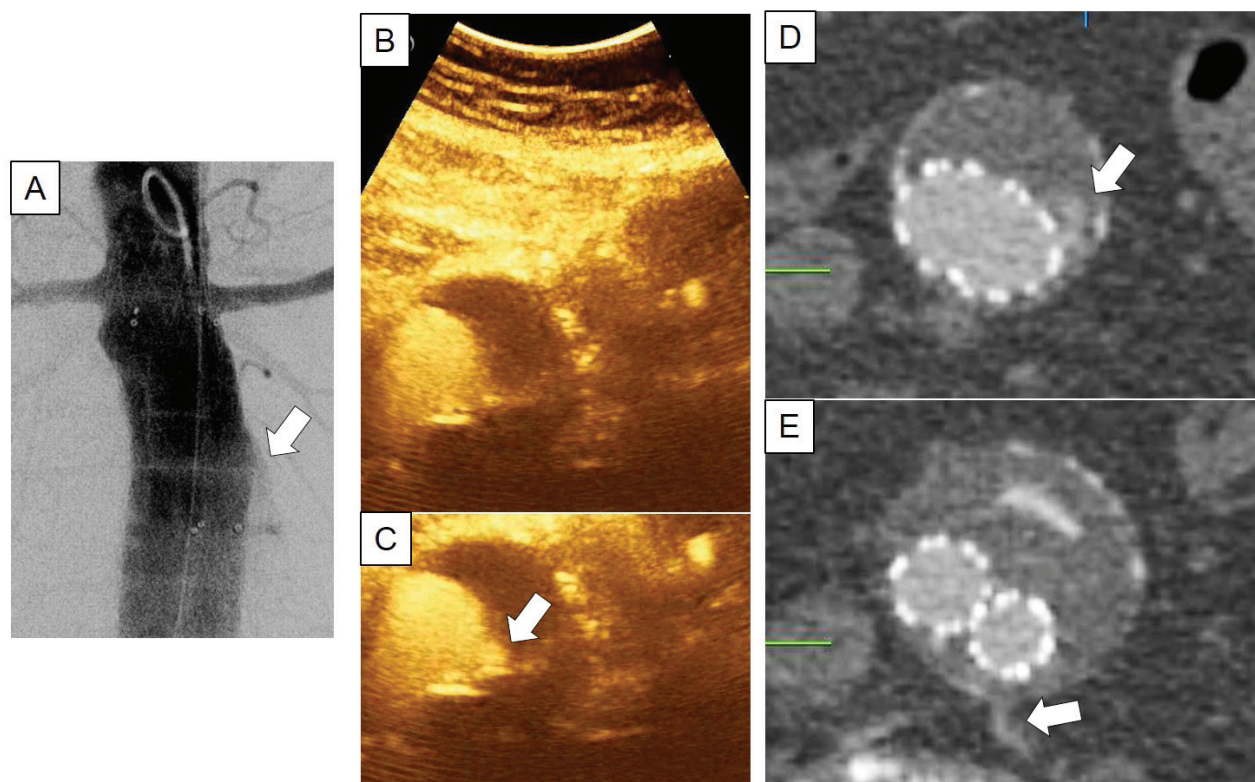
Type Ia EL at DSA was reclassified as type II EL after intraoperative CEUS (case #3). A) completion angiography showed proximal sac reperfusion and EL was classified as type Ia. B, C) intraoperative CEUS identified a late sac reperfusion on the left proximal side (white arrow); the EL was classified as type II EL. D, E) post-operative CTA proved the presence of type II EL from lumbar arteries.
